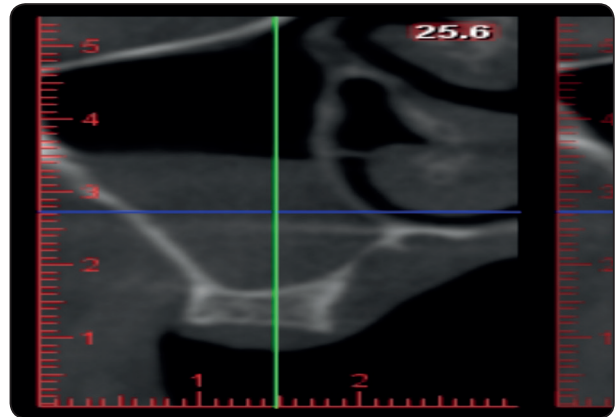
Preoperative CBCT show the residual ridge height
